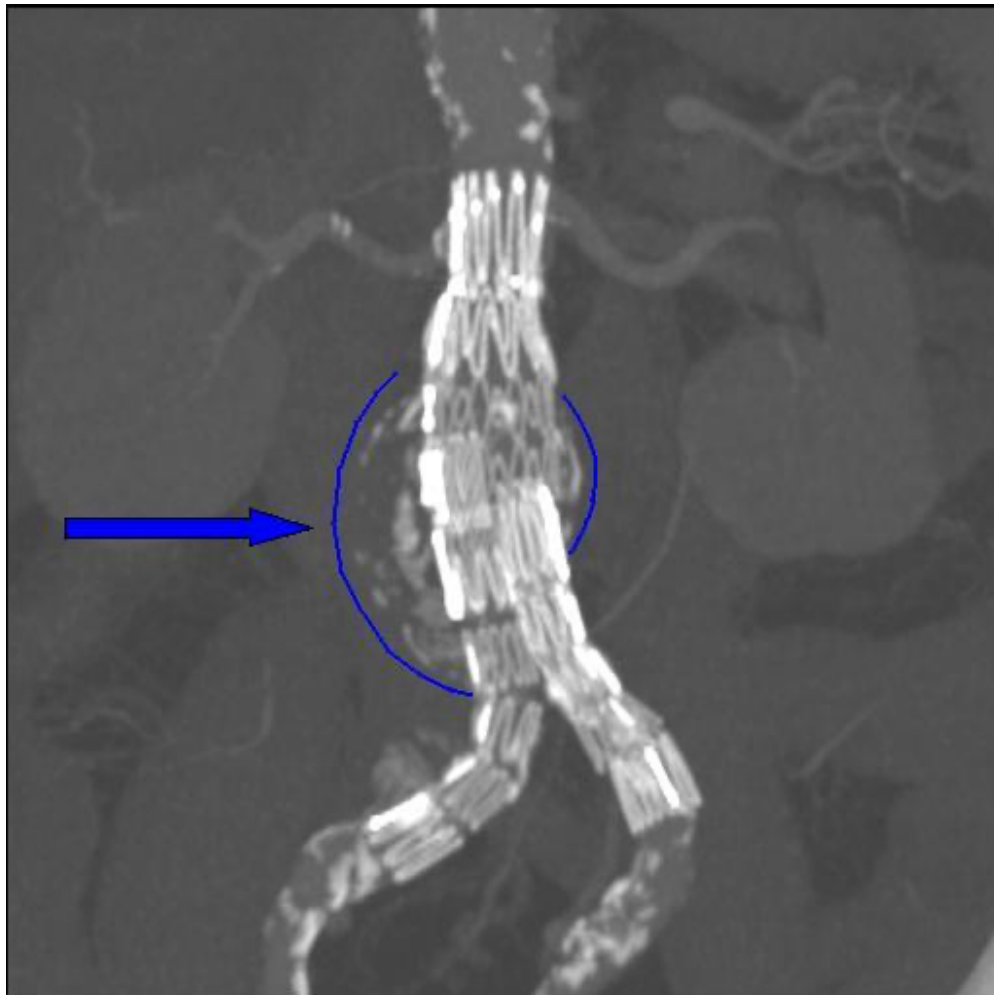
Dr. Haudebourg: Abdominal aortic endoprosthesis, CT scan [Internet]. (Source: Wikipedia, accessed: 02 June 2024). Available from: <https://en.wikipedia.org/wiki/File:Endovasc.jpg>.
